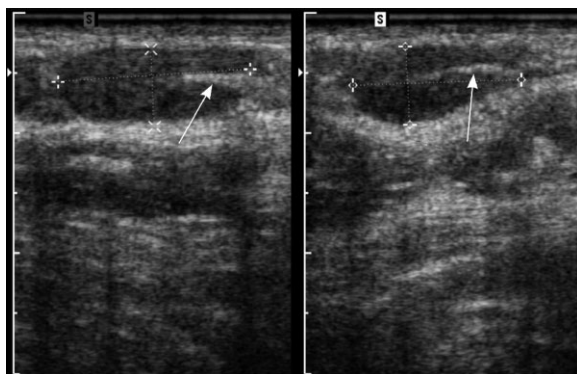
An ultrasound image (in two perpendicular planes) of a cervical lymph node (between markers) with ultrasound features of a reactive lymph node: longitudinal in shape with homogenous cortex and with a preserved hyperechoic linear hilum (arrow), in a 46-year-old male with a small lymphocytic lymphoma.
